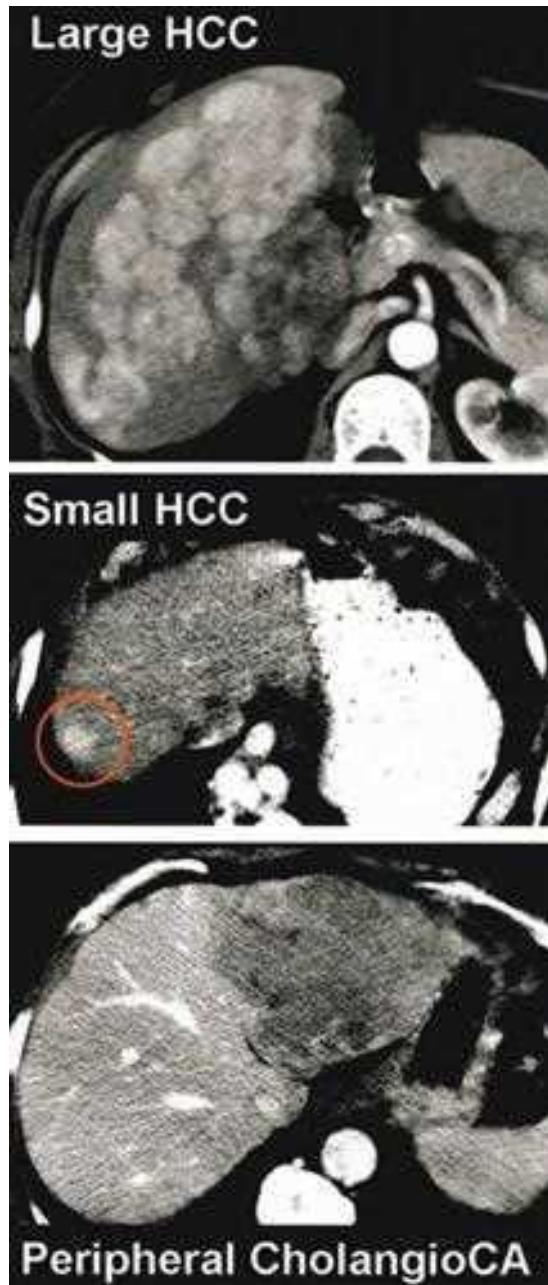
Computed tomographic (CT) images of hepatocellular carcinoma (HCC) and peripheral cholangiocarcinoma. CT scans reveal a large (*upper panel*) and small (*middle panel*) hypervascular HCC. A hypovascular left lobe peripheral cholangiocarcinoma (CholangioCA) is also shown (*lower panel*).
